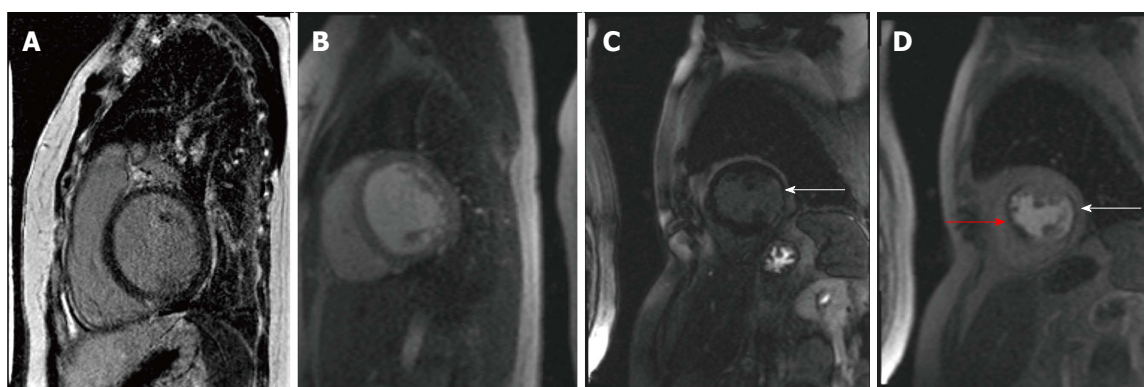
Two patients underwent cardiac stress magnetic resonance imaging for evaluation of significant left ventricular dysfunction systolic dysfunction. Patient 1 with Idiopathic dilated cardiomyopathy, EF 30%: Panel A shows post gadolinium contrast images with absence of delayed enhancement in the left ventricular myocardium and Panel B shows lack of perfusion defect with adenosine stress imaging. Patient 2 with Ischemic cardiomyopathy, EF 15%: Panel C shows subendocardial delayed enhancement in the inferolateral wall (arrow) and Panel D shows stress perfusion defect in the anteroseptum (red arrow) consistent with ischemia and another matched perfusion defect caused by the inferolateral infarction (arrow).
